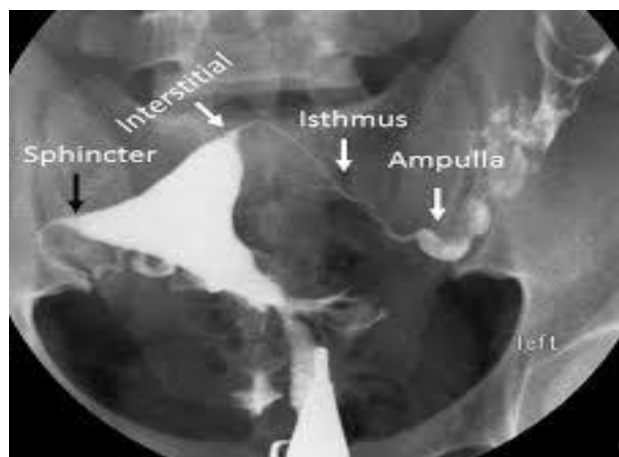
HSG X-ray film showing uterus and both tubes⁽¹³⁾
